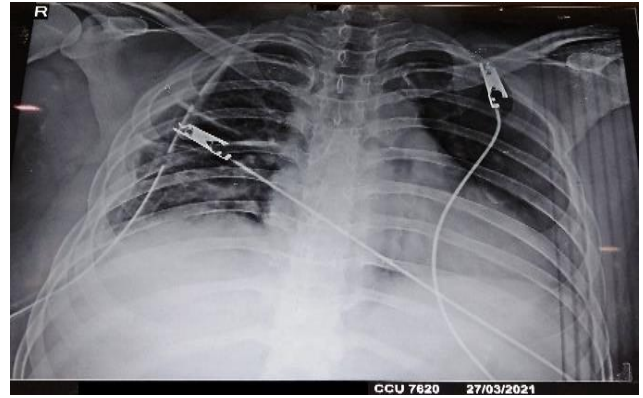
Chest x-ray post physiotherapy.
